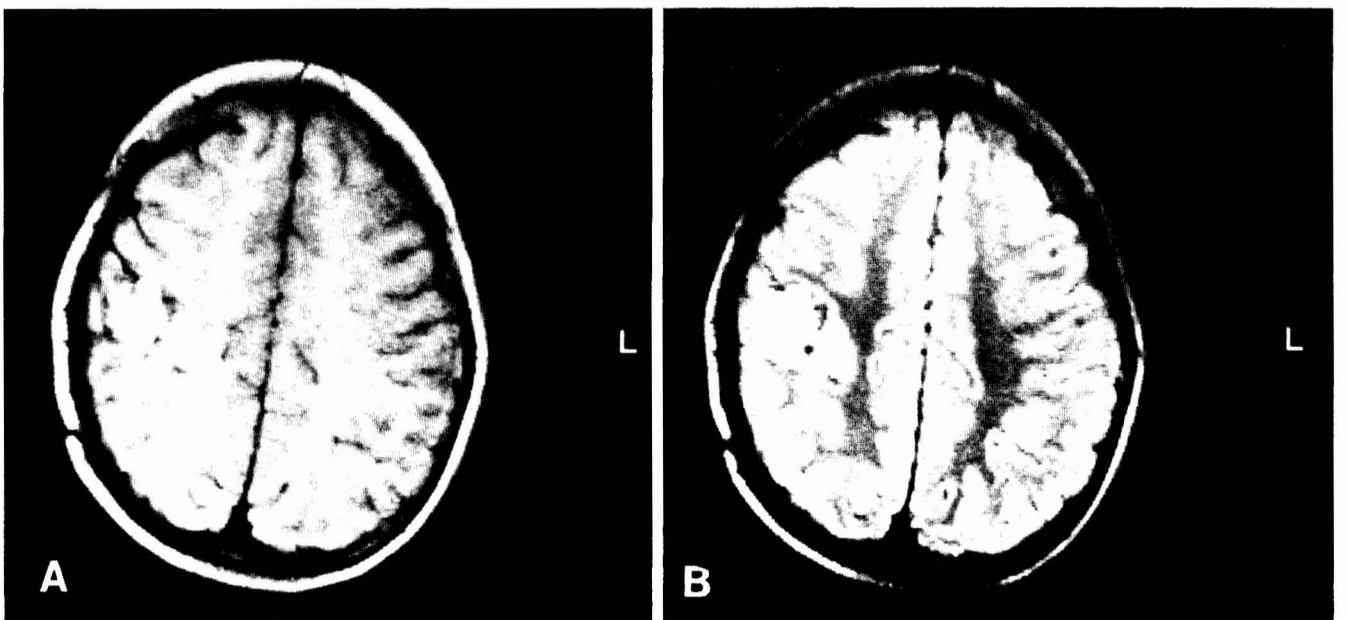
Case 4. *A*: T1-weighted image consistent with subacute hemorrhage and tissue matrix. *B*: T2-weighted image showing central free methemoglobin with a rim of hemosiderin and peripheral edema.
